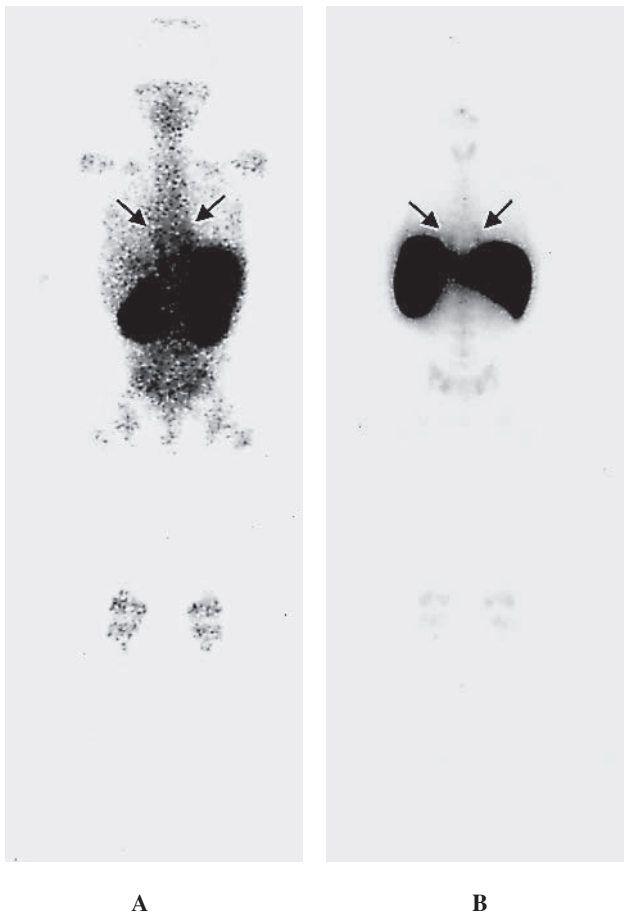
In-111 chloride (A) and Tc-99m Sn colloid (B) scintigraphies (posterior views) showed radiotracer uptake in the masses (arrows) demonstrated on CT and MRI, and the diagnosis of intrathoracic extramedullary hematopoiesis was confirmed. Expansion of the bone marrow into the distal extremities was also revealed.
